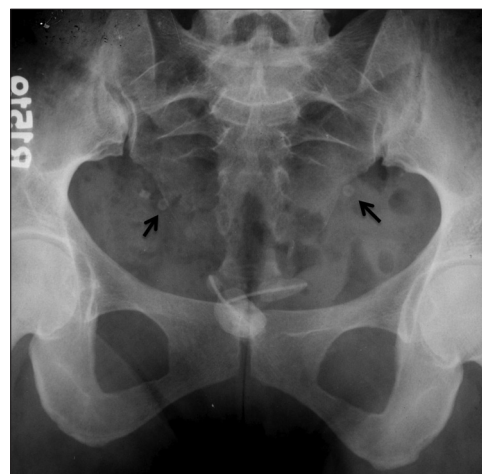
X-ray pelvis showing multiple vesical calculi implanted upon the T-shaped intrauterine contraceptive device with faloperings (arrow) *in situ*
